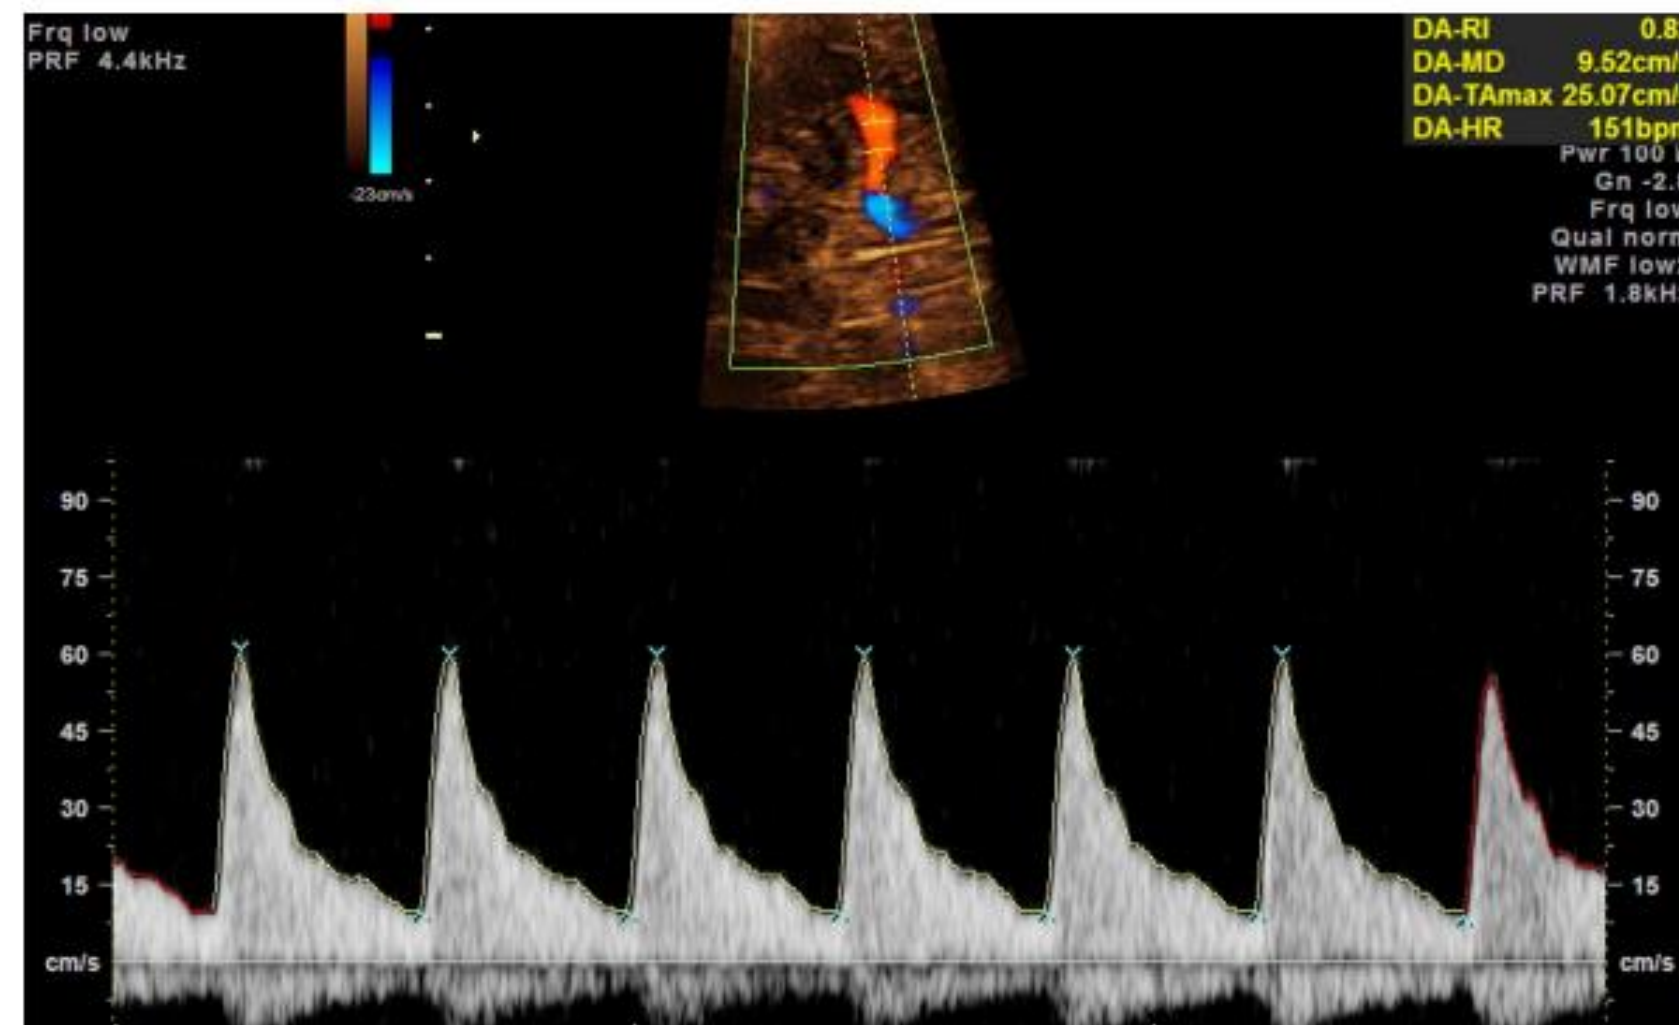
Acceptable Doppler waveform from the middle cerebral artery. Note the angle of insonation has been adjusted to be nearly 0° .
